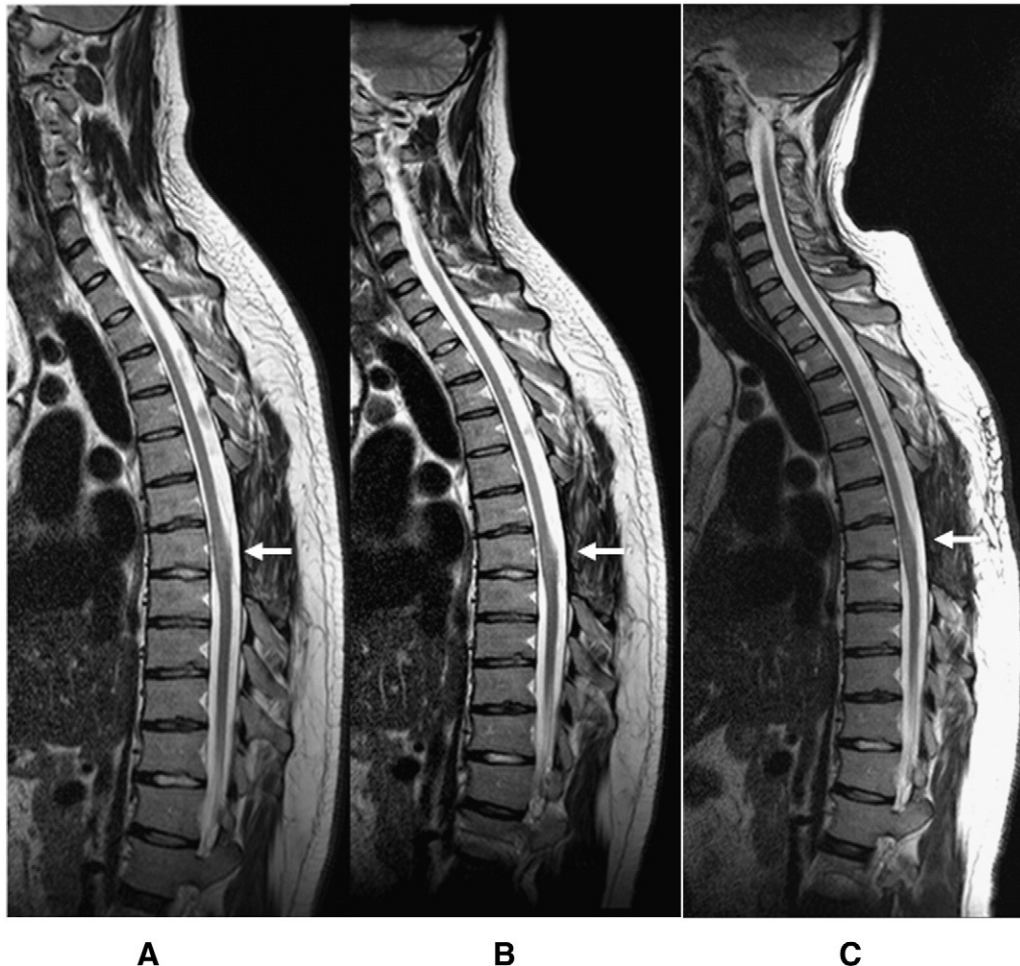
TSE T2-weighted sequences acquired on sagittal plane 3 (image A), 6 (image B) and 12 (image C) months after stem cell implant. Intradural signal hyperintensity at the site of the graft is shown (white arrow). Long-term findings show a slight reduction of SC hyperintensity (white arrow).
